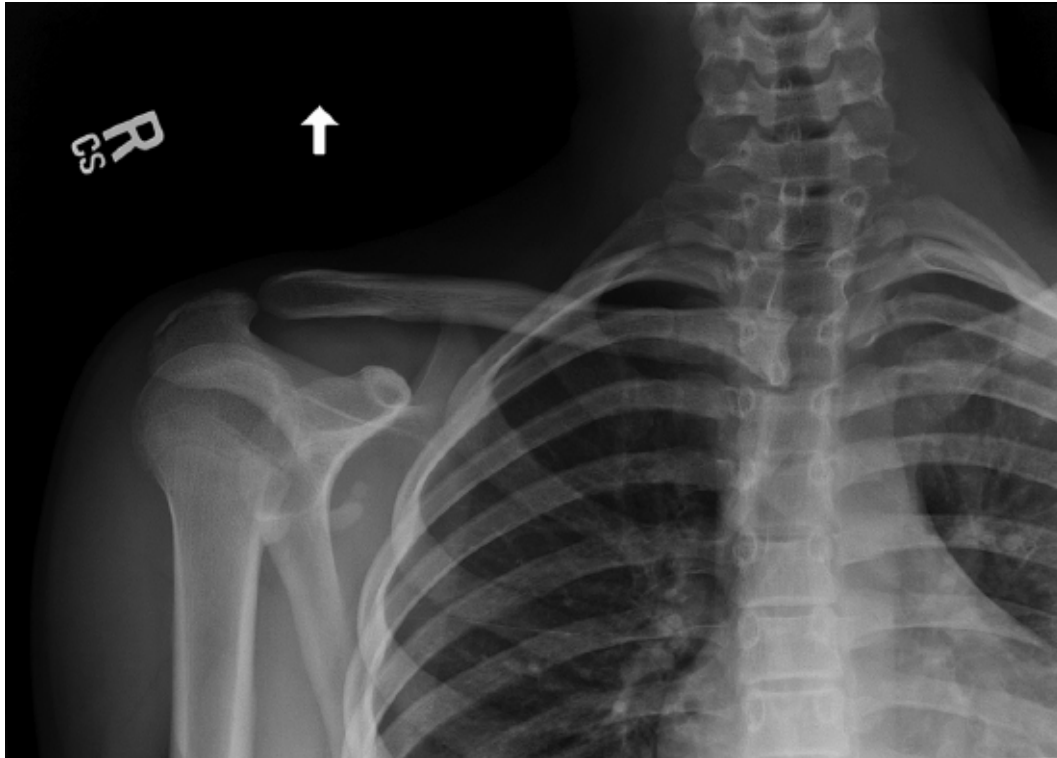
SC Serendipity radiograph demonstrates posterior and superior dislocation of the the right SC joint.
